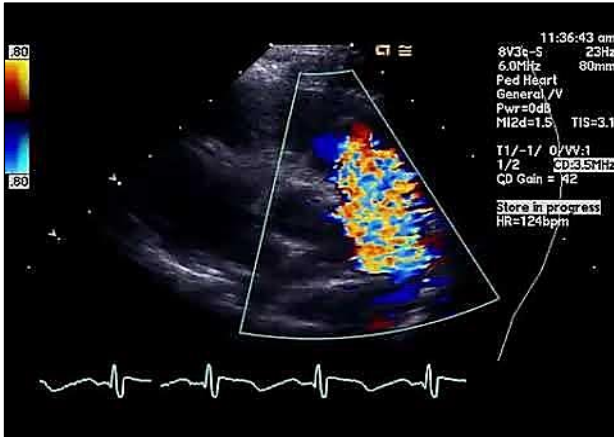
Pulmonary stenosis echocardiogram
